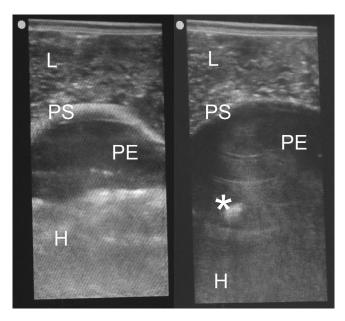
Ultrasound images from Centesys showing: (left) subxiphoid window showing liver (L), pericardial sac (PS), pericardial effusion (PE), and heart (H); (right) subxiphoid window showing similar anatomical structures with needle in-situ (shown by *) within pericardial effusion.
